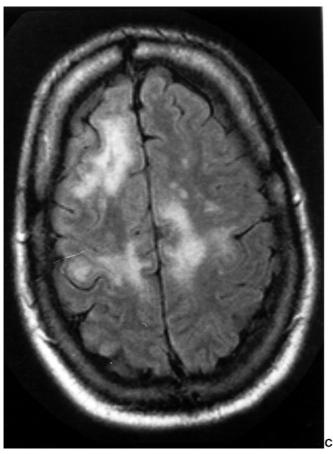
Progressive Multifocal Leukoencephalopathy: 32 year old man with dementia and progressive left leg weakness. CT, which is not shown, revealed nonenhancing edema right frontal region.
